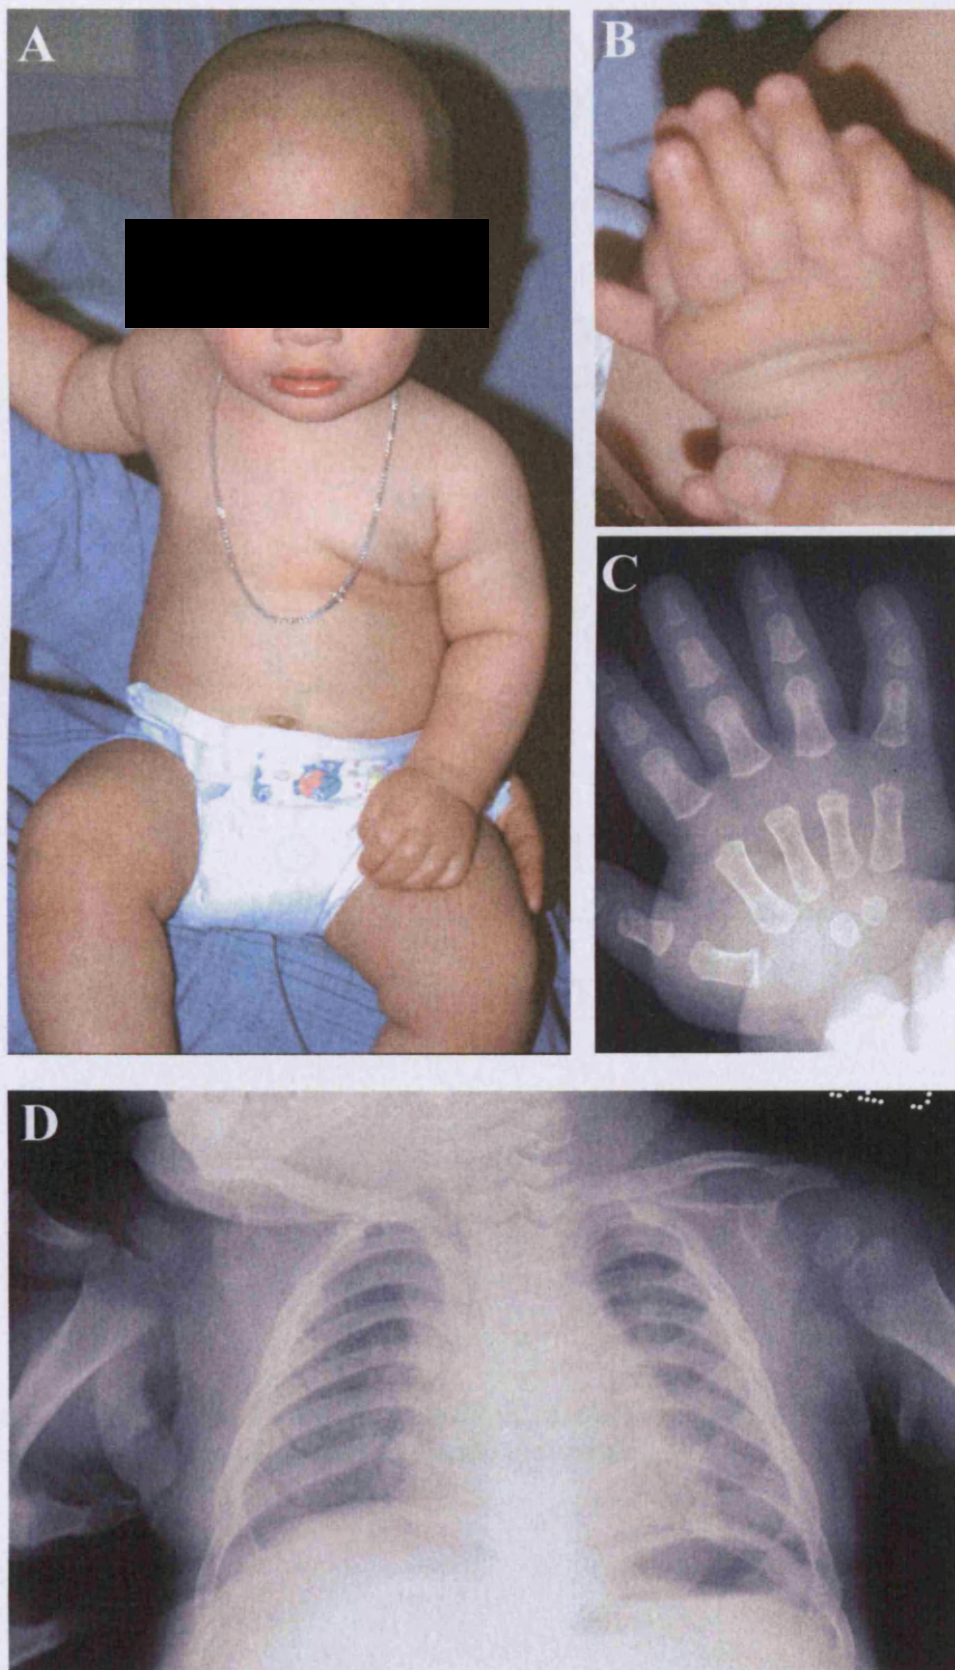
Clinical photographs and radiographs of patient IV.1 from Family 1. There is mild rhizomelic limb shortening (A) and the hands are broad (B) with 5th finger clinodactyly (C). The upper thorax is rather narrow (D).
